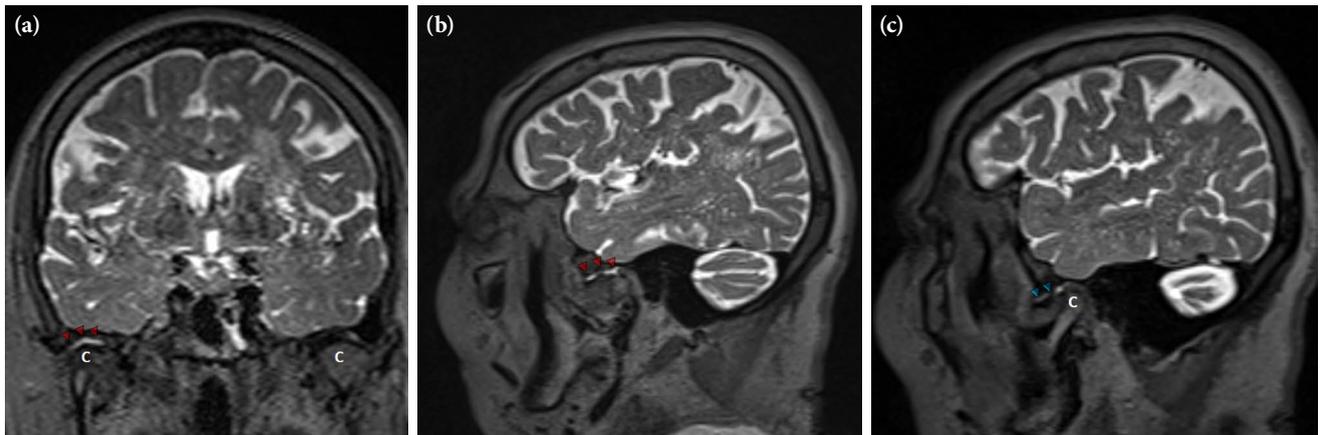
(a) Coronal and (b and c) consecutive sagittal T2-weighted SPACE MRIs show effusion (red arrow heads) of the right TMJ. The last frame sagittal MRI image (c) also demonstrates anterior disc displacement (blue arrow heads).
